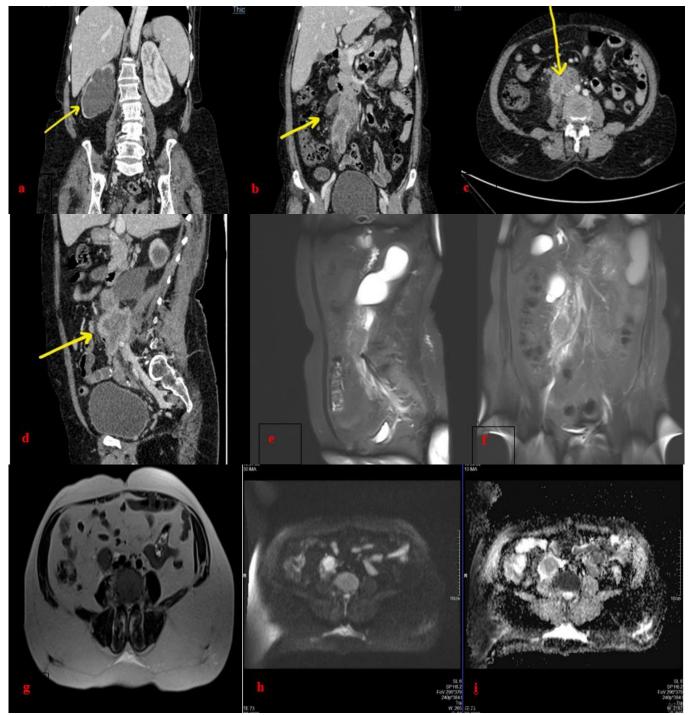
shows radiological imaging of 70 years old female presented with complain of abdomen pain and haematuria. (a) coronal section of CT image shows gross hydronephrosis in right kidney. (b) coronal section, (c) axial section and (d) sagittal section of CT images show ill-defined enhancing lesion involving right mid ureter. (e) sagittal section and (f) coronal section of STIR-MR images shows a well defined lobulated altered signal lesion in right mid ureter resultant in gross hydronephrosis in right kidney. (g) axial section of T2-wighted image shows heterogenous hyperintense signal. (h & i) shows that lesion shows diffusion restriction.
